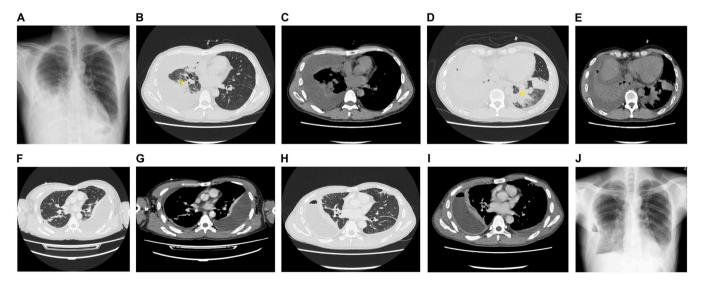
Radiographic images of the chest. (A) Chest radiography on the day of admission shows massive right pleural effusion. (B–E) The lung window (B and D) and mediastinal (C and E) window images of chest plain computed tomography (CT) on the day of admission show massive right pleural effusion and bronchopneumonia (*) in the bilateral lower lobes. (F and G) The lung window (F) and mediastinal (G) window images of chest contrast-enhanced CT on day 8 of admission reveal improvements in the bilateral pneumonia and a reduction in the right pleural effusion, whereas left pleural effusion emerges. (H and I) The lung window (H) and mediastinal (I) window images of the chest plain CT on day 19 of admission show the reaccumulation of the right pleural fluid. (J) Chest radiography on the day of discharge shows no recurrence of pleural effusion.
